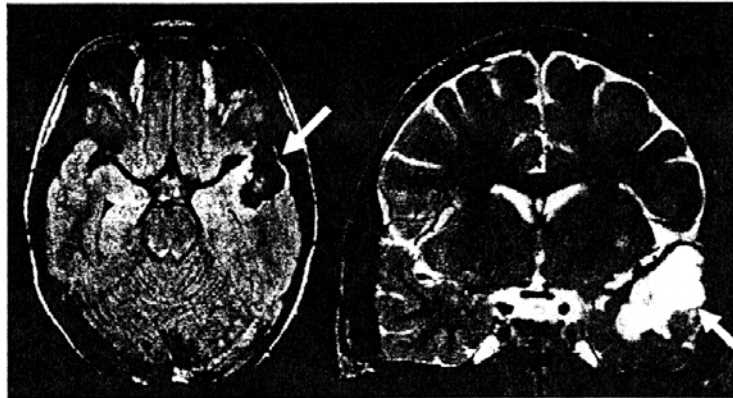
Patient 1. MRI. The figures show a cystic lesion with solid mural nodule on left temporal lobe.
